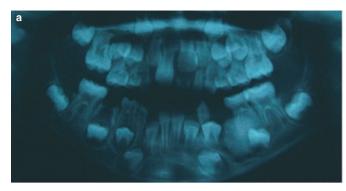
Clinical and radiograph appearance of lesion. (a) Panoramic radiograph, (b) intra-oral photograph.
